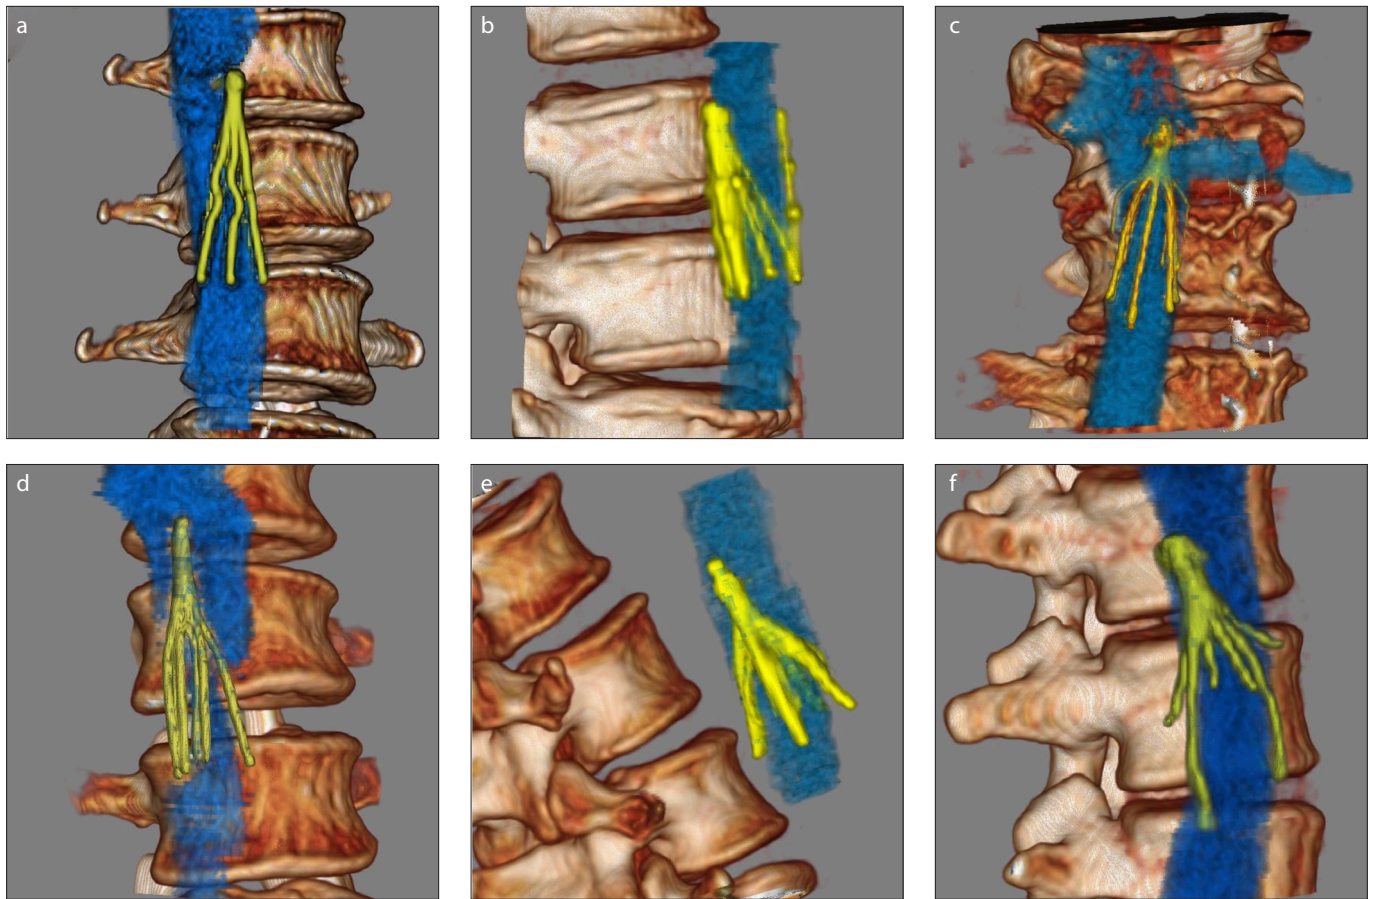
a–f. 3D reconstructions of *in vivo* IVC filters from CT data demonstrating examples of complications. (a), Greenfield (Boston Scientific) filter demonstrating tilt; (b), Vena Tech (B. Braun Medical) filter demonstrating tilt; (c), Denali (Bard Peripheral Vascular) filter demonstrating tilt; (d), Option (Argon Medical Devices) filter demonstrating perforation; (e), Celect (Cook Medical) filter demonstrating tilt and perforation; (f), ALN (Aln International) filter demonstrating tilt and perforation.
